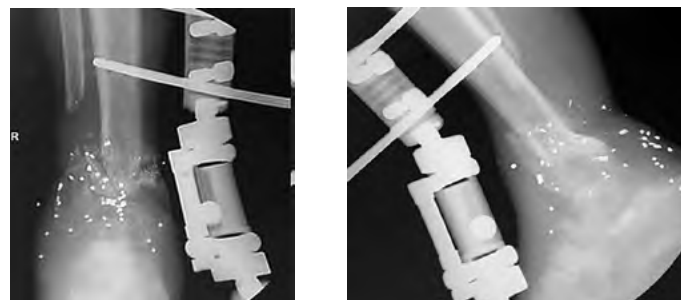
Postoperative plain radiographs. Latest post-op. Anteroposterior (AP) and Lateral views of the right lower leg/ankle(A-B)
